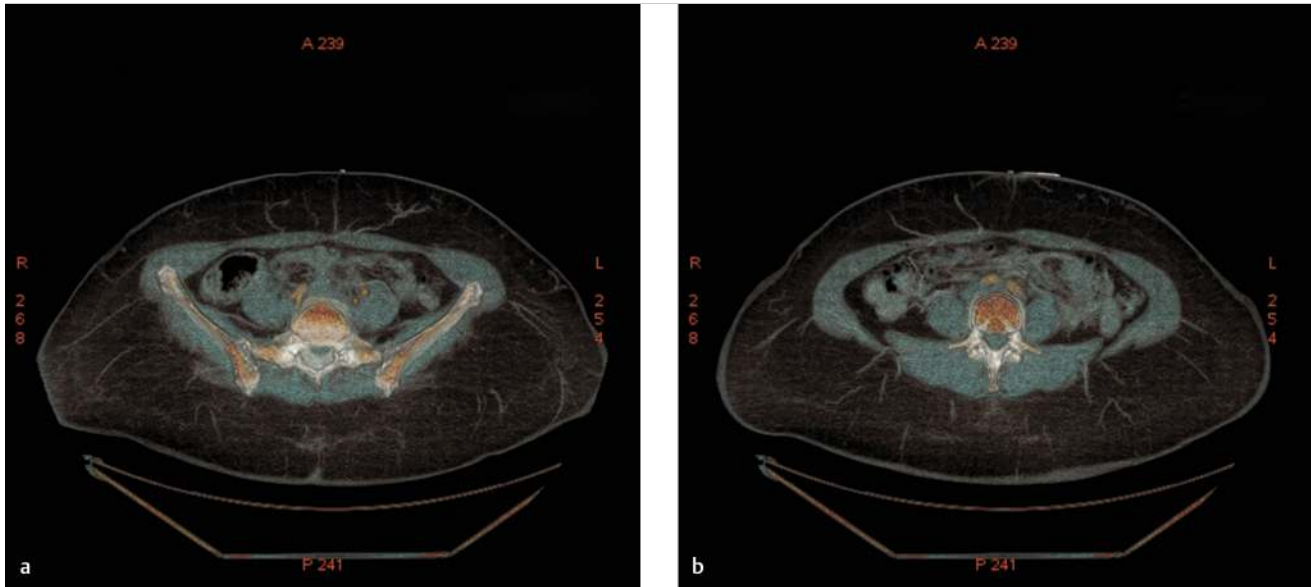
(a, b) Computed tomography (CT) angiogram demonstrating perforators arising from the deep inferior epigastric vessels passing through the rectus abdominis muscle, supplying the overlying soft tissue.
